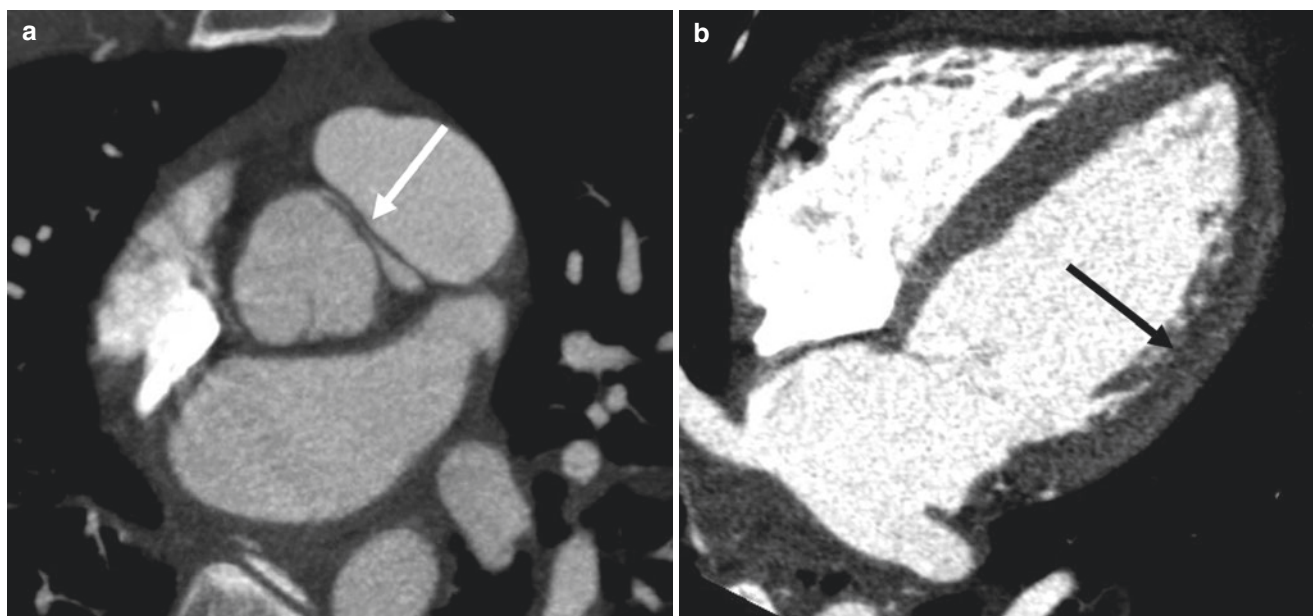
Coronary anomalies. Thin-slab MIP image from a coronary CT study performed on an ED patient with chest pain demonstrates anomalous origin of the right coronary artery from the left cusp with interarterial course. This course has been associated with arrhythmia and sudden cardiac death
